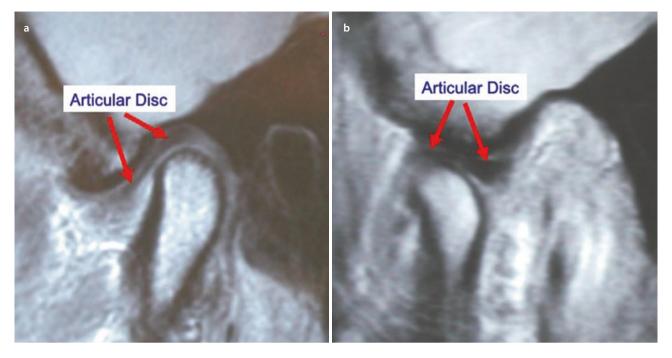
MRI sagittal view of a normal healthy TMJ. a The joint space is equal posterior, superior, and anterior with the posterior band of the disc at 12 o'clock position relative to the condyle.
